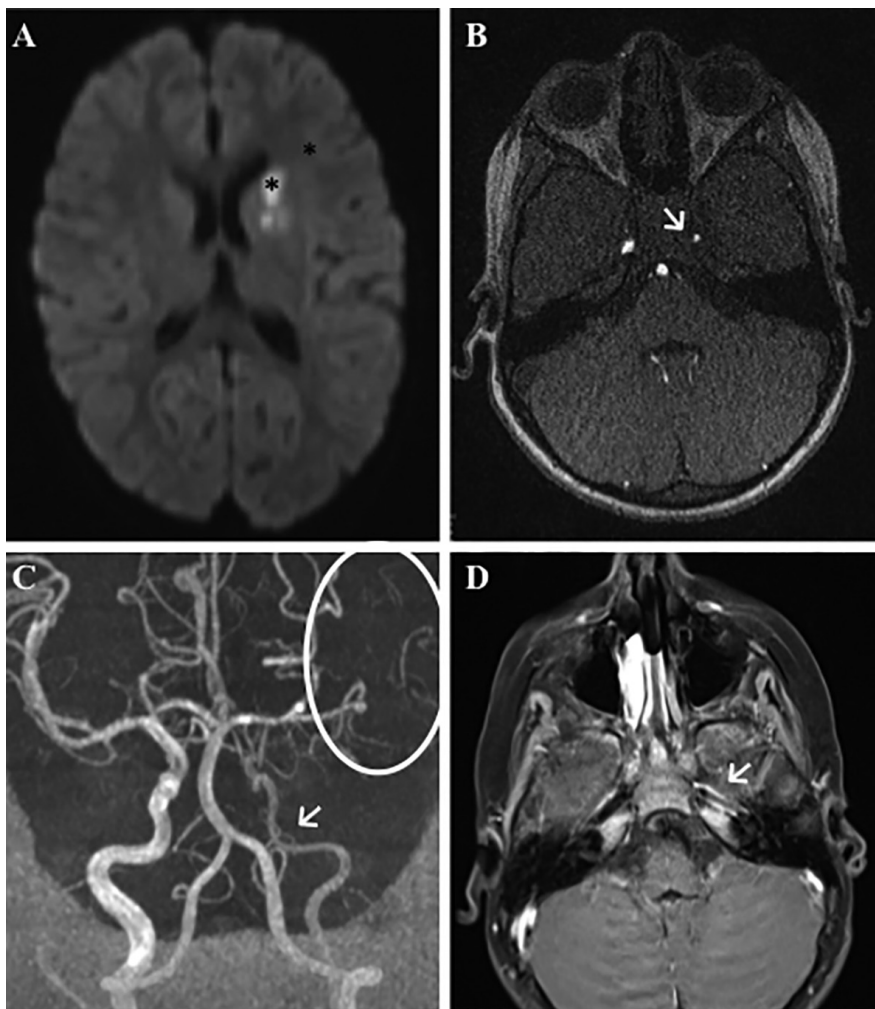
MRI findings in a 9-year old girl with PACNS, 2 days after the onset of symptoms. A) Axial diffusion weighted imaging (DWI,  $b=1000s/mm^2$ ), showing fresh lesions in the right frontoparietal region with reduced diffusivity (\*). B) Single image from 3 dimensional time-of-flight (TOF) and C) Maximum intensity projection (MIP) of 3D time-of-flight (TOF) angiogram, unveiling an occlusion and stenosis of the right internal carotid artery (→). In C) arterial wall thickening of the right internal carotid artery with luminal obstruction can be seen (↓).
